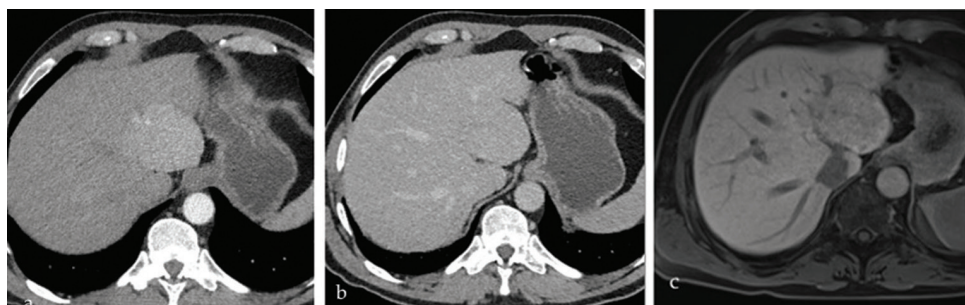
Focal nodular hyperplasia. Computed tomography in (a) arterial and (b) portal phases show a well-defined homogeneous mass with arterial enhancement and isodensity on portal phase. c. Subsequent magnetic resonance imaging in hepatobiliary phase shows the mass to be isointense to liver, proving that it is focal nodular hyperplasia.
